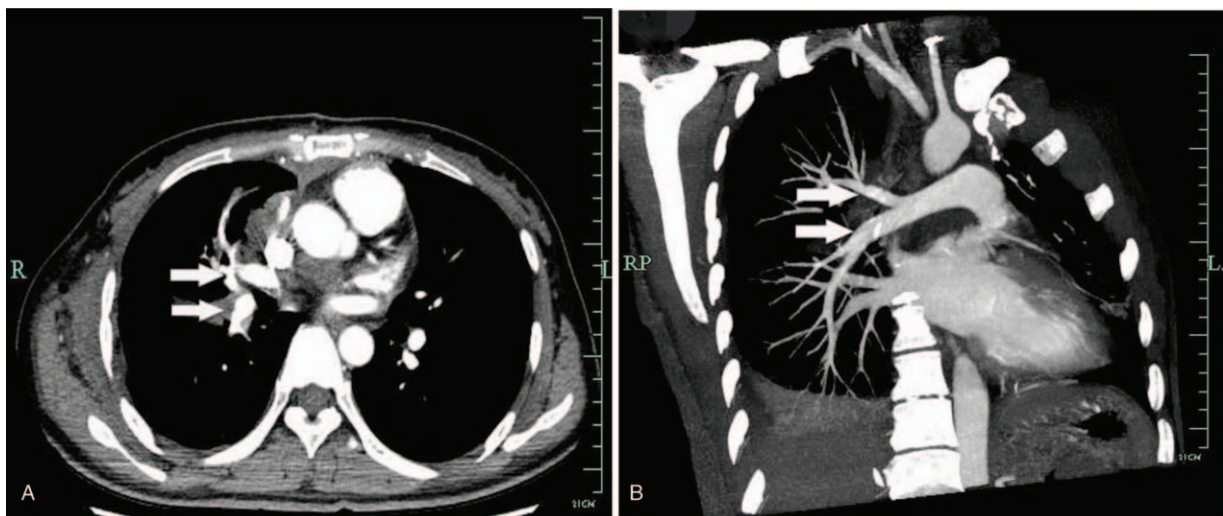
Pulmonary computer tomography angiography after embolectomy. A and B showed the main branches of right pulmonary artery were good filled (arrow) in pulmonary CTA after embolectomy. CTA=computer tomography angiography.
